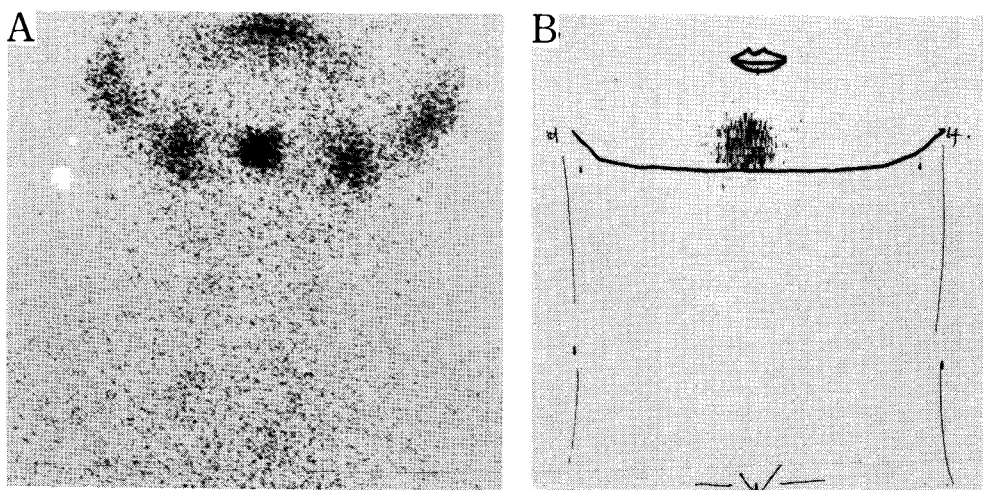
Case II. Anterior view (a) of scintigraph reveals a abnormal focus with accumulation of  $^{99m}\text{Tc}$  pertechnetate in midline of mandible, which is corresponding to a iodophilic focus on  $^{131}\text{I}$  scintiscan (b). The thyroidal activity is not seen over the neck.
